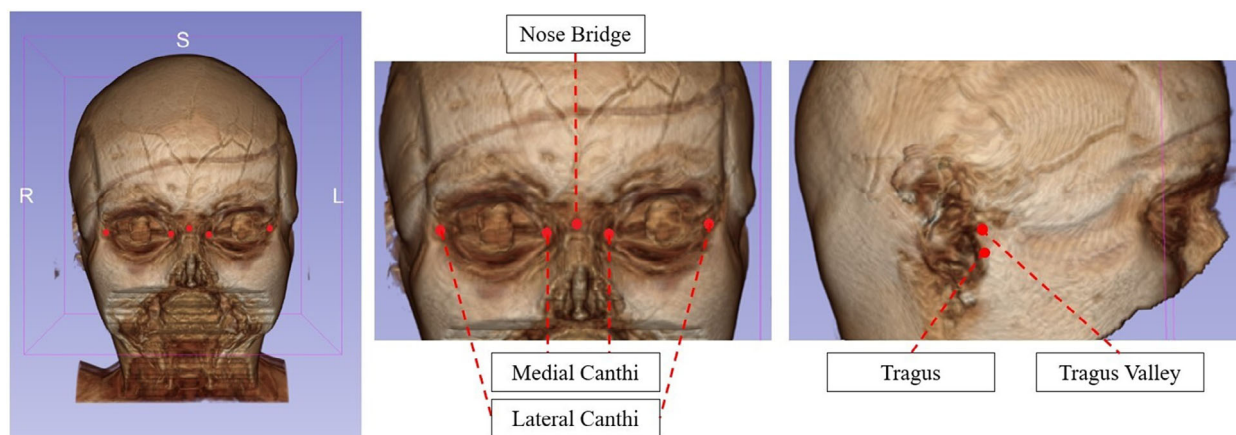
Front and side views of defaced MRI volume of one subject and the facial landmarks denoted by the red dots. MRI, magnetic resonance imaging.
